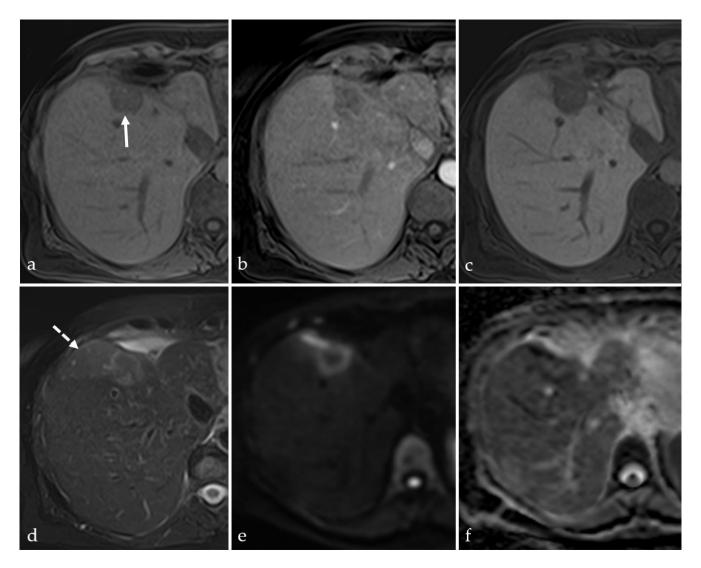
Left hepatectomy and partial right liver lobe resection. MRI examination of a patient who underwent PEI for an HCC nodule (arrow) in the liver segment VIII 5 months prior. The treated nodule has no contrast enhancement in the arterial (b) or hepatobiliary (c) phase, has low signal intensity on both T1 (a) and T2 (d) fat saturated images, has peripheral restricted diffusion (e,f), and an adjacent wedge-shaped area of hypoperfusion (dotted arrow).
